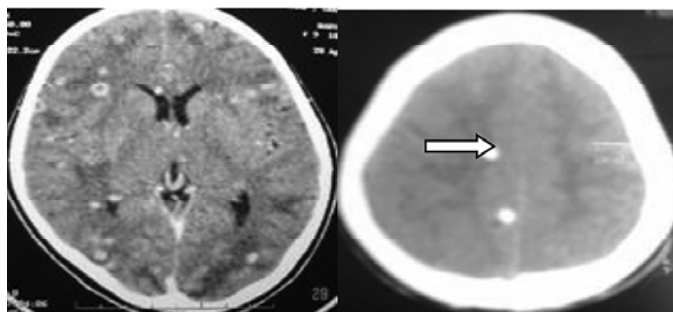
Contrast CT showing ring enhancing lesions with surrounding edema Fig.13. Plain CT showing calcified granulomas
